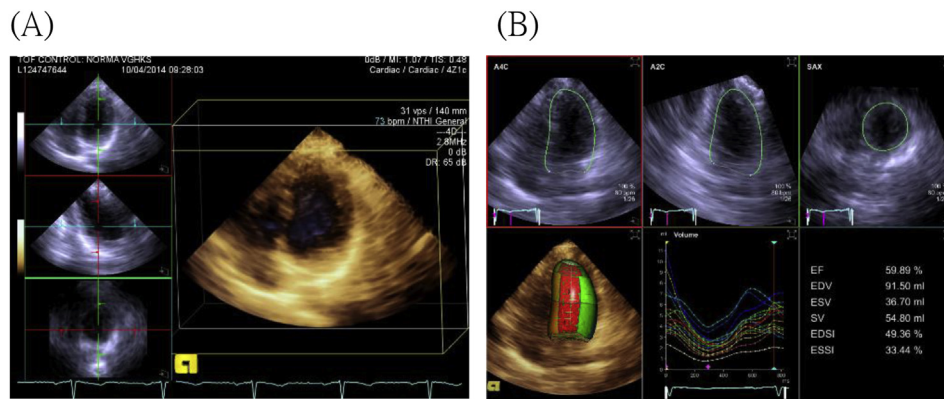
The stepwise process of left ventricle (LV) reconstruction by 3D echocardiography. (A) Real time 3D echocardiographic images are reviewed in four planes (short-axis and apical two-chamber, three-chamber, and four-chamber views), and brightness and contrast are optimized. (B) LV endocardial border is automatically demonstrated (green line) by the LV analysis program when the “contour revision” is selected (auto-contouring algorithm). The endocardial border is optimized with additional manual correction if needed. LV volume is calculated and displayed.
